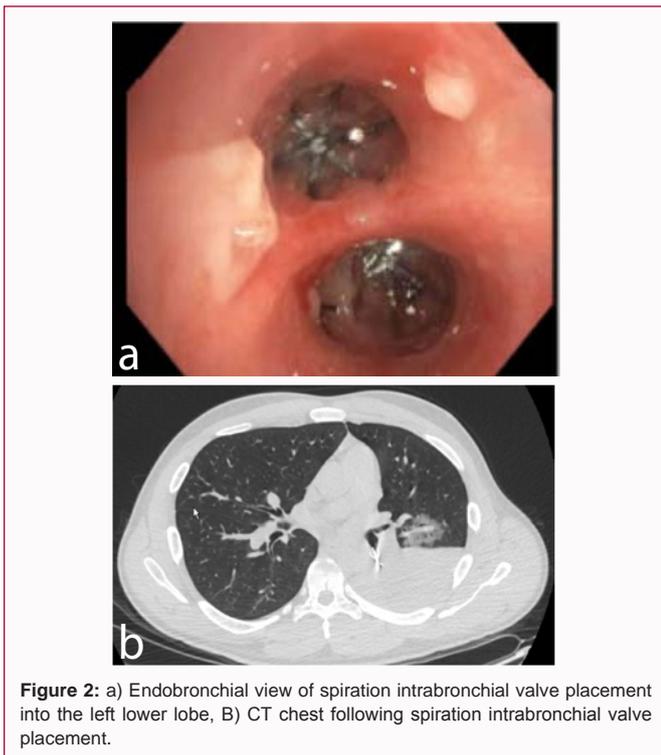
a) Endobronchial view of spiration intrabronchial valve placement into the left lower lobe, B) CT chest following spiration intrabronchial valve placement.
